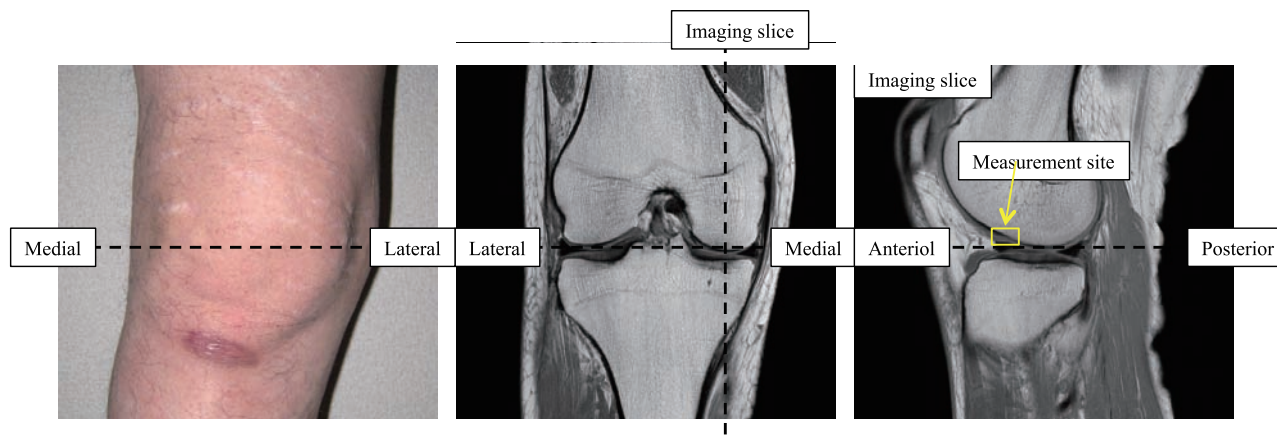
DT-MRI imaging slice and data measurement site
